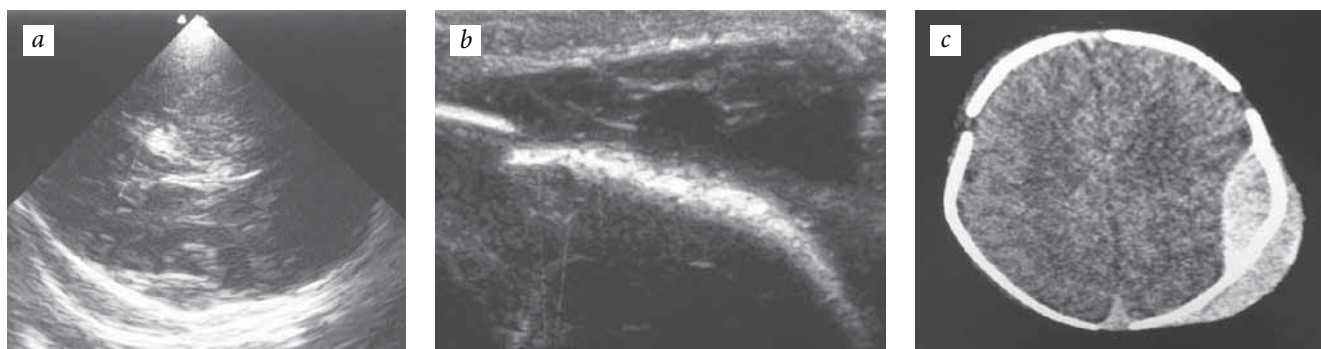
Cephalhematoma associated with epidural hematoma and linear parietal bone fracture, 5-day-old newborn, *a* — transcranial and transfontanelar ultrasonography, transtemporal scanning, and visualized subperiosteal and epidural hematomas; *b* — skull ultrasonography (right parietal bone linear fracture); *c* — computed tomogram of the head, confirming ultrasonography data
